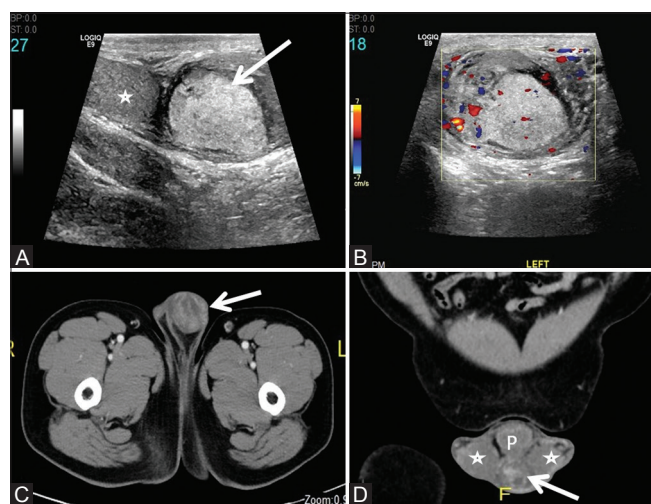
(A-D): (A) Grey scale ultrasound shows hyperechoic mass (arrow) separate from the testis (asterisk). (B) Color Doppler ultrasound shows minimal internal vascularity. (C) Axial and (D) coronal contrast-enhanced CT shows heterogeneously enhancing extratesticular mass (arrow) separate from the testes (asterisk). P: Penis
